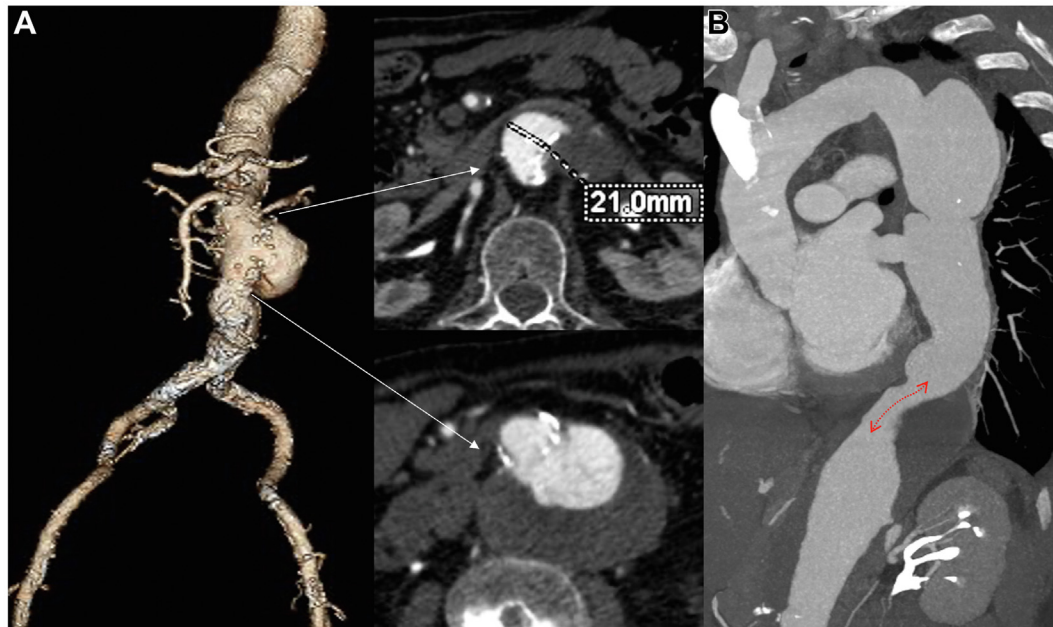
(A) Computed tomography angiography (CTA) three-dimensional reconstruction of a thoracoabdominal aortic aneurysm (TAAA) with a narrow paravisceral aorta (NPA) associated with severe aortic wall calcifications. (B) CTA multiplanar reconstruction of a TAAA with a NPA extended for >25 mm (red arrow).
